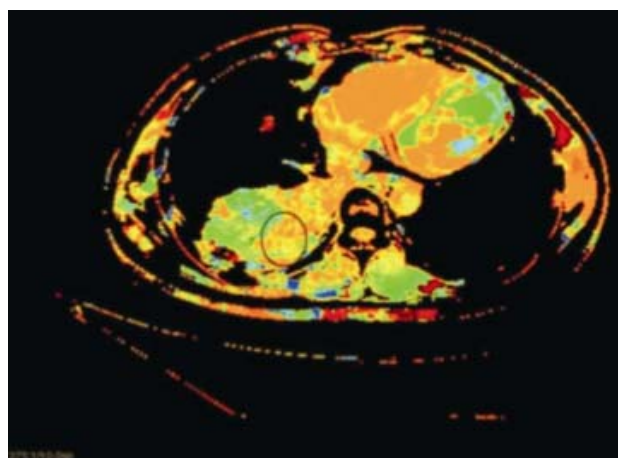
Axial CT of thorax with perfusion map placed over mass in right lower lobe perfusion map showing MTT = 3.6 sec
